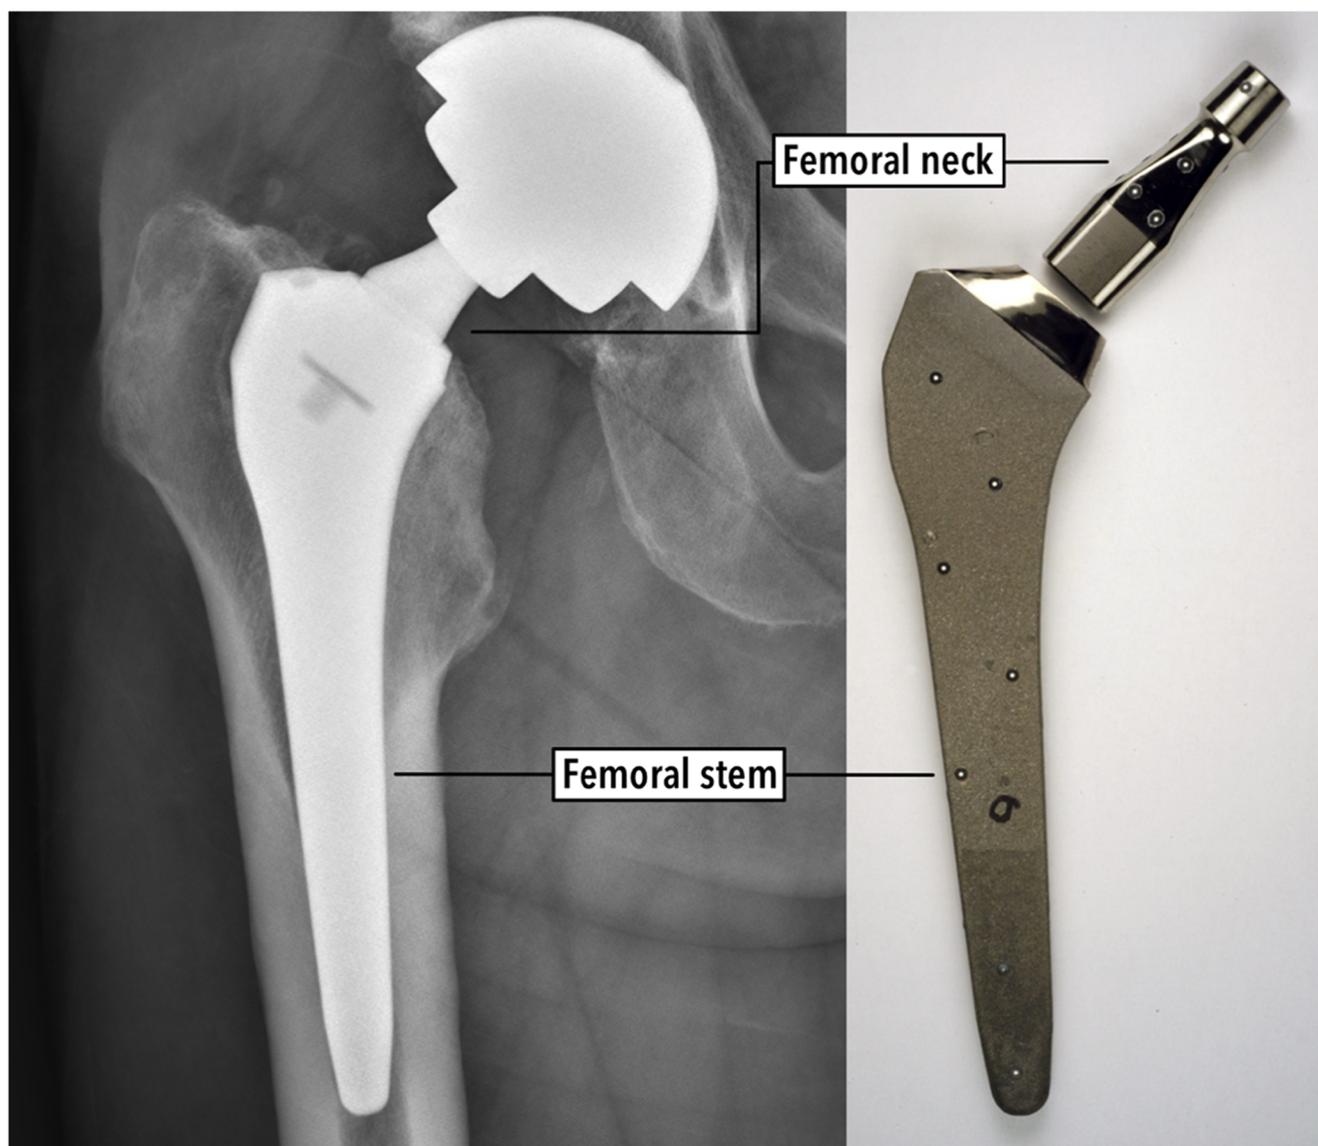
Dual modular total hip arthroplasty. AP radiograph (left) of the right hip with a dual modular total hip arthroplasty. Disassembled components of the femoral neck and stem (right) of a dual modular
